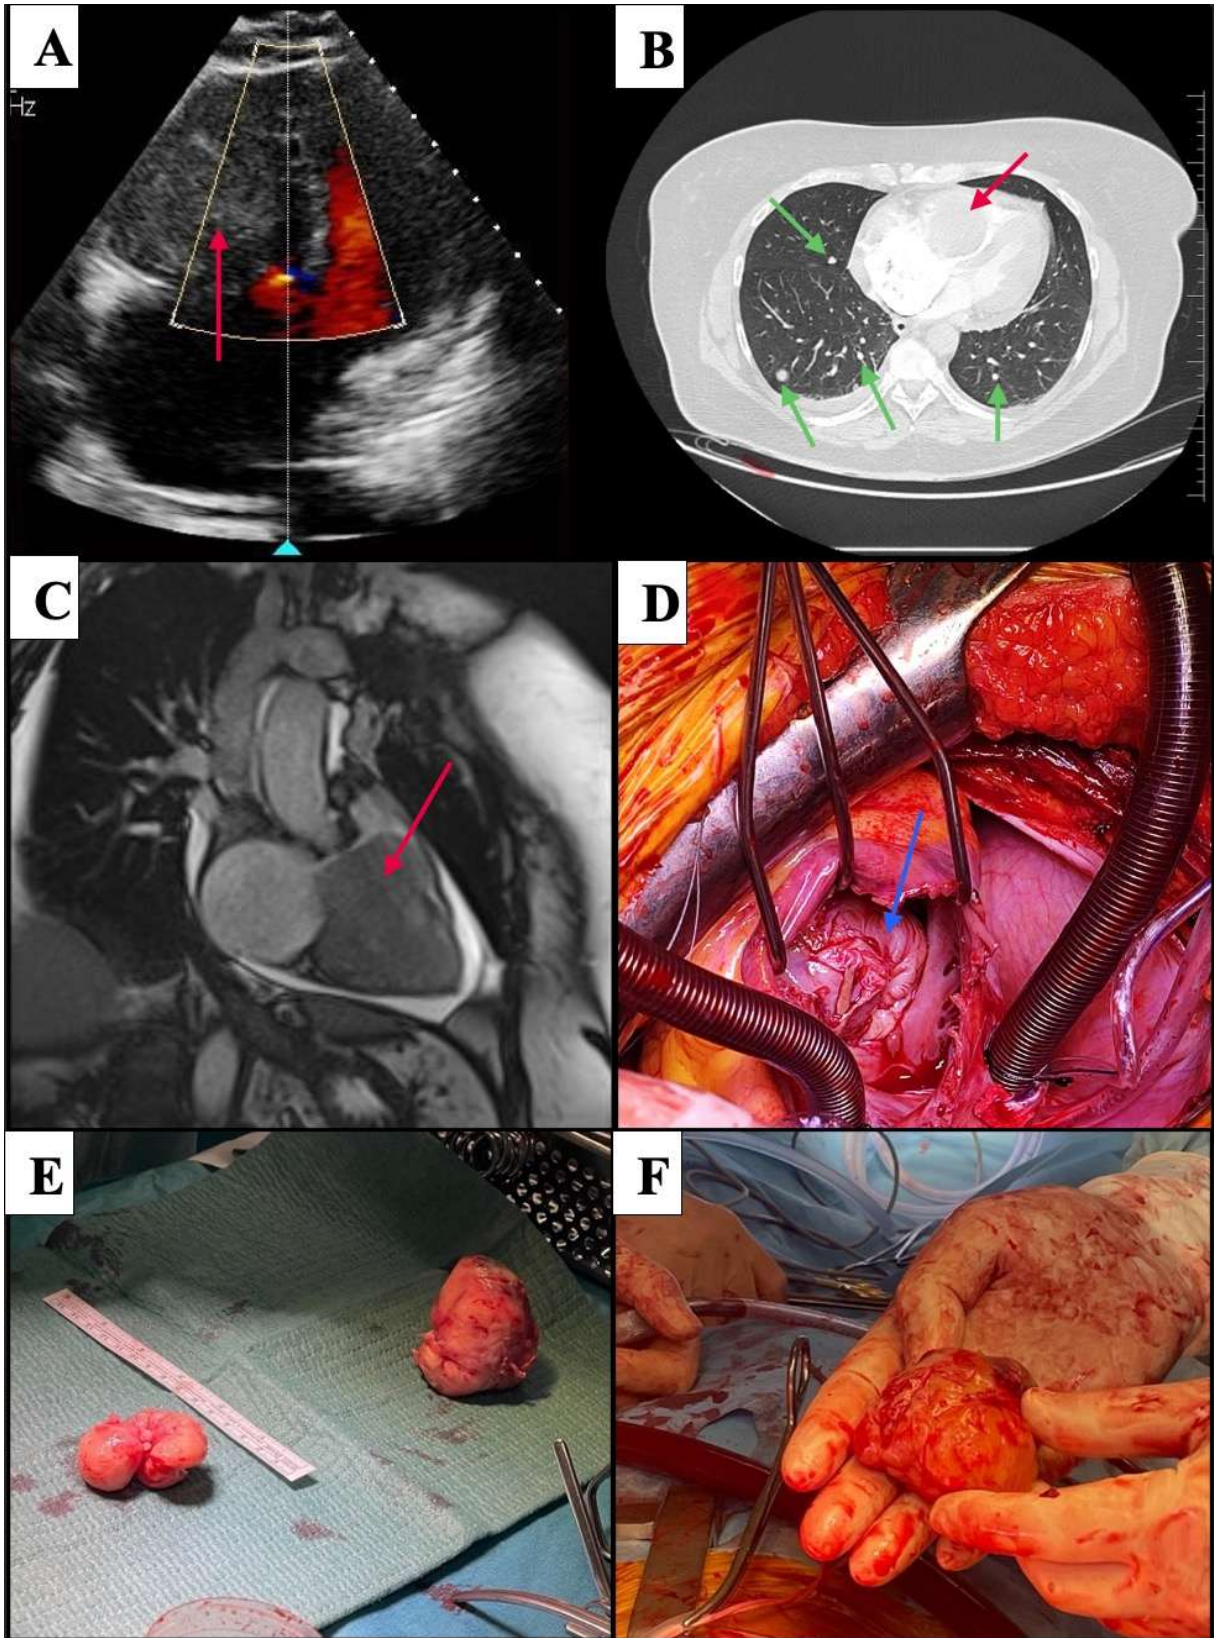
A. Echocardiography showing enlarged right ventricle with flow obturation due to enormous tumor (red arrow). B. Computed tomography scan of the tumor (red arrow) also showing multiple metastases (green arrows) and fluid retention in the lungs. C. Magnetic resonance imaging shows tumor mass (red arrow). D. Intraoperative photo of the tumor placed
